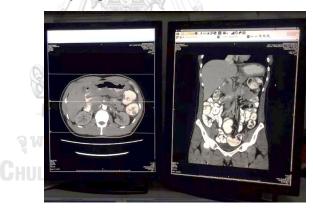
Abdominal computed tomography with contrast enhancement.
